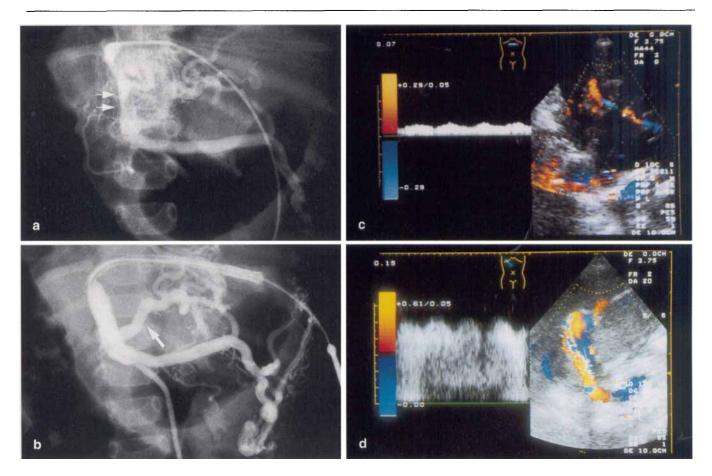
Radiographs of angioplasty for portal vein stenosis and Doppler US findings of the portal vein in case 3: a Transhepatic portography prior to PTA demonstrates a stenosis about 3 cm long in the portal vein anastomosis (*arrows*); b Subsequent portography reveals complete resolution of the stenosis. A dilated left gastric vein is also found (*arrow*); c Before PTA, the flow velocity in the intrahepatic portal vein is decreased. The sample volume is positioned at the umbilical portion; d After PTA, color flow images of the portal vein become prominent and the flow velocity increases significantly
